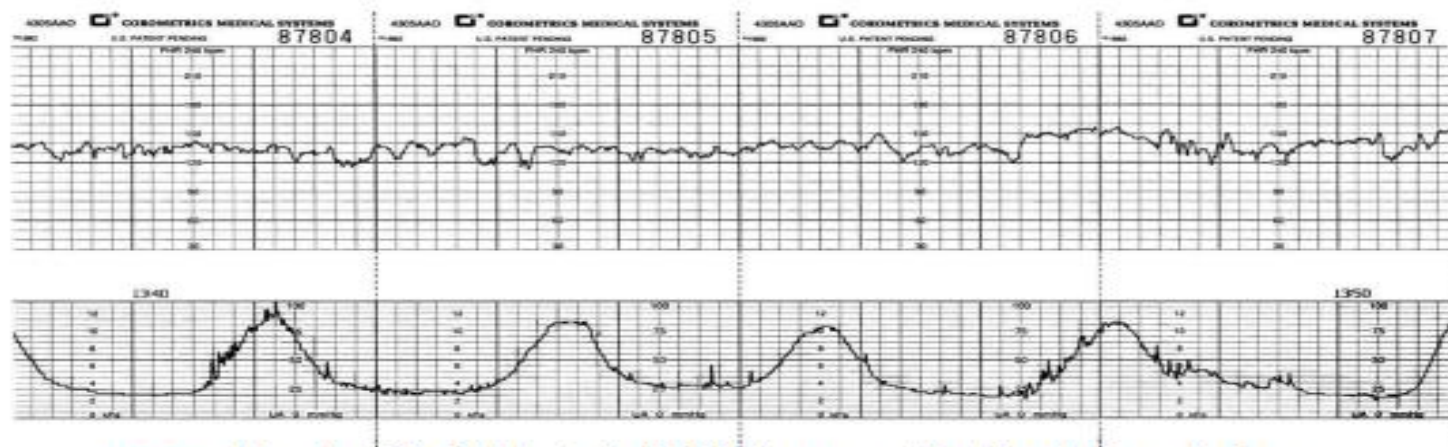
Recording of the fetal heart rate (FHR) in the upper grid and the uterine contractions in the lower grid. The sawtooth appearance of the FHR tracing is a result of the constant changes in the rate (variability). NOTE: The space between each dark black line on the strip represents 1 minute. The space between each light black line (i.e., the small squares) represents 10 seconds. (Courtesy Corometrics Medical Systems, Wallingford, CT. Redrawn with permission.)
